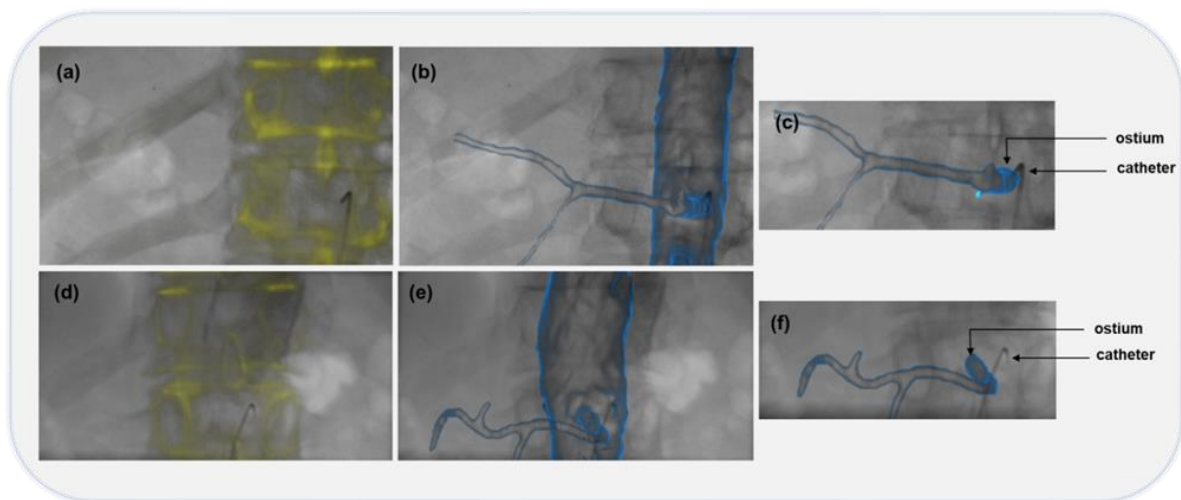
Évaluation de l'accès au tronc cœliaque pour deux cas de patients différents. Le volume CTA préopératoire est aligné avec l'image fluoroscopique peropératoire au moyen d'un recalage osseux (a) (d). La projection de l'aorte abdominale et des branches latérales (b) (e) entraîne un chevauchement de l'ostium du tronc cœliaque et du cathéter dans le premier cas (c) alors qu'un léger décalage entre les deux composantes est noté dans le second cas (f).
